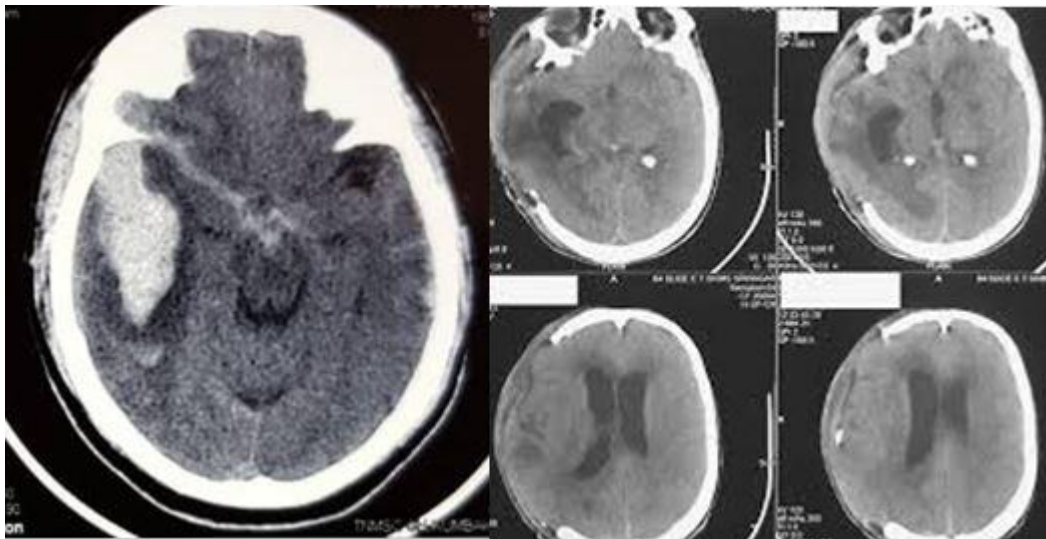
64 years male who underwent decompressive hemicraniectomy, CT brain plain axial section at the time of admission (left) and CT brain done on day 50 showing hydrocephalus (right)
